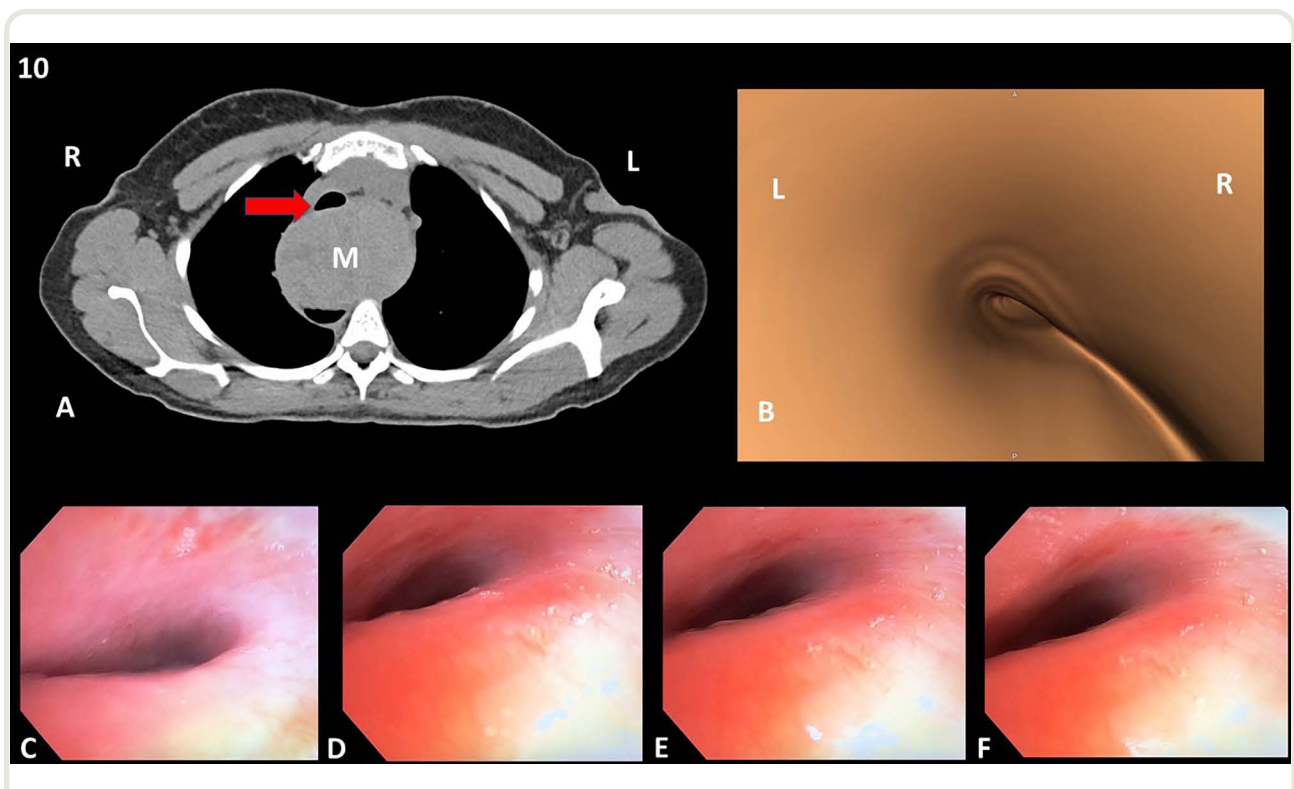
(A) Contrast axial chest computed tomographic scan of subject no. 10 demonstrating a mediastinal mass primarily posterior to the central airway. *M* indicates the mass. *Red arrow* indicates compressed trachea. (B) Digital virtual bronchoscopy of the region of central airway stenosis from the same patient. (C) Actual bronchoscopic still picture of the central airway during baseline awake, and spontaneous ventilation; (D) during general anesthesia maintaining spontaneous ventilation; (E) during general anesthesia with positive pressure ventilation; and (F) during general anesthesia with positive pressure ventilation and neuromuscular blockade. See Supplemental Digital Content for all 17 patients' computed tomography scans, virtual bronchoscopies, and still pictures and associated videos demonstrating clinically insignificant changes in airway patency during staged inductions.
